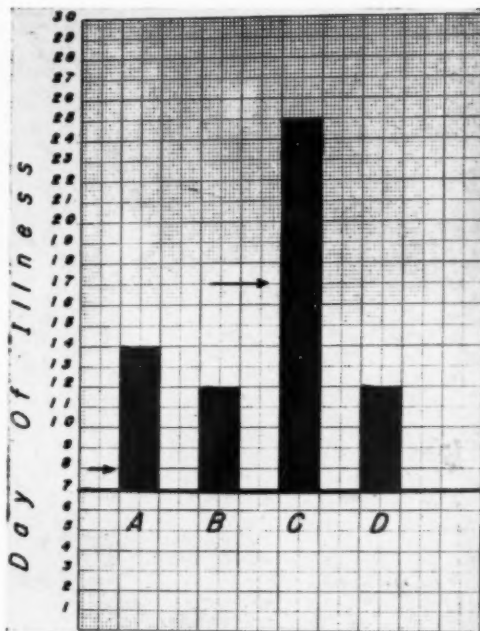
Chart showing relation of roentgenologic findings to physical signs, fever, and leukocytosis. Average duration of illness at time of hospital entry, 7 days. A. Leukocytosis (present in 80 per cent of cases); arrow indicates day of highest count. B. Fever. C. Abnormal roentgen findings; arrow indicates day of average beginning resolution. D. Physical signs.
